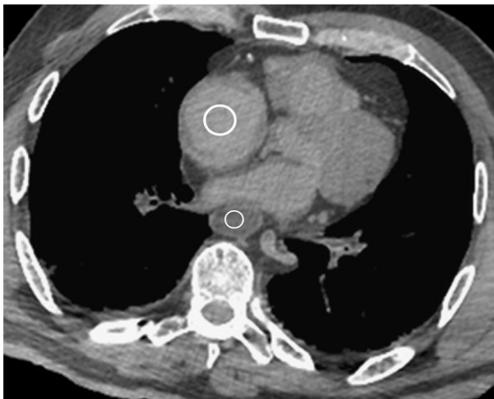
Post-mortem axial CT scan of the chest in mediastinal window, demonstrating the placement of ROI's for measuring the density of the intracardiac blood and esophageal contents
